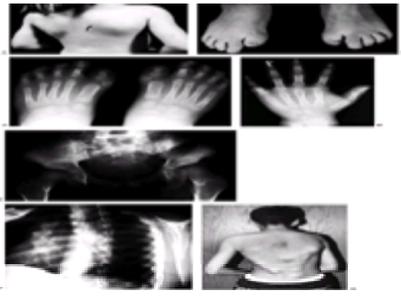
Fibrodysplasia ossificans progressiva. Four-year-old female at the time of presentation. She complained of right periscapular swelling, warmth, and tenderness. A: Clinical photograph demonstrating the area of right periscapular involvement (*arrow*). B: Characteristic great toe morphology, demonstrating shortening of the great toes bilaterally. C: Bilateral radiographs of the feet demonstrating shortened great toes, with bilateral delta phalanges and shortened first metatarsals. D: Anteroposterior radiograph of the hand, demonstrating characteristic shortening of the thumb metacarpal. E: Anteroposterior radiograph of the pelvis, demonstrating short, broad femoral necks, and exostoses. F: Early spontaneous fusion along the posterior elements and lateral masses is demonstrated. G: Clinical appearance of an older individual with advanced subcutaneous ossification and characteristic dorsal-to-ventral pattern.
